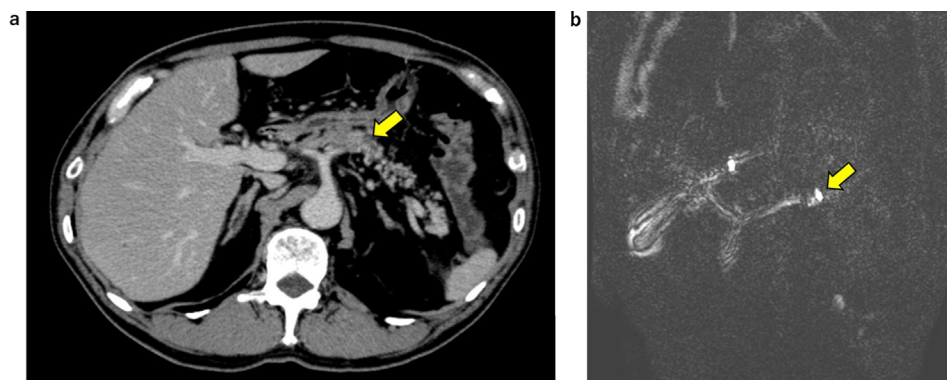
Examination of pancreas. Abdominal enhanced CT shows atrophy and dilation of the main pancreatic duct in the pancreatic body and tail. A 14-mm nodular lesion is associated with parenchymal atrophy in the pancreatic body (a). Abdominal contrast MRI with diffusion-weighted imaging shows a 15-mm high-intensity signal area at the same site, suggesting pancreatic duct cancer (b).
